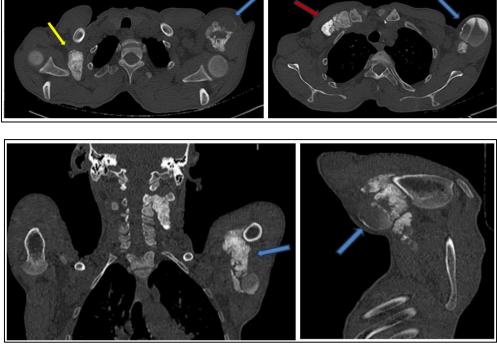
Cervicothoracic CT scan in bone tissues window, in 3 different planes showing 3 formations in the left shoulder (blue arrow), the right shoulder(yellow arrow) and near the right sterno-chndro-clavicular joint(red arrow), totally calcified on the right and partially calcified on the left, containing a liquid-liquid level associated with sedimentation deposits.
